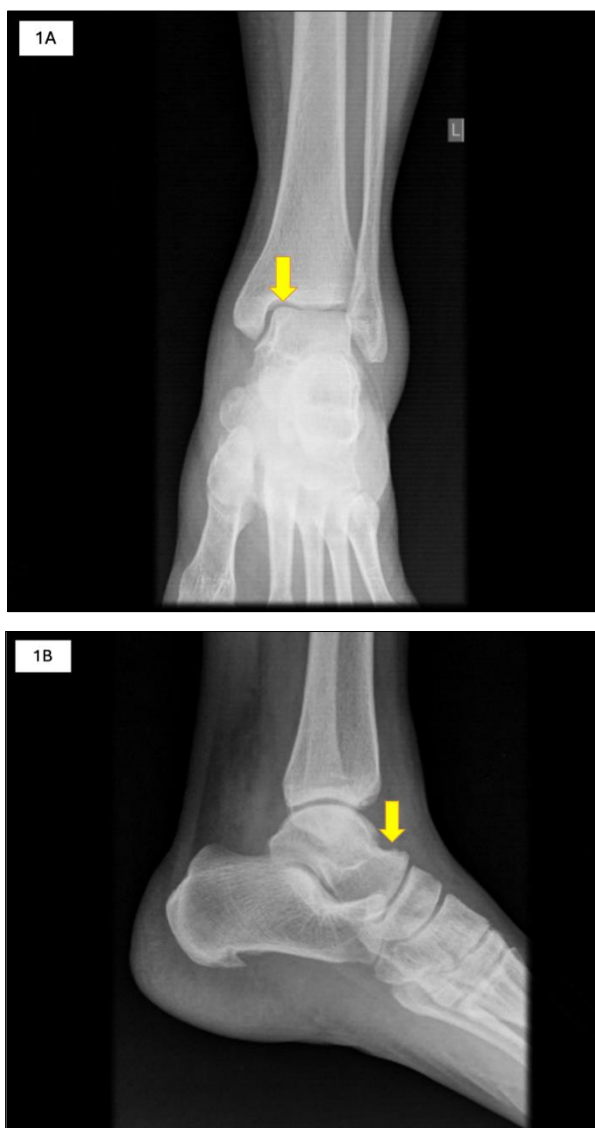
A 46-year-old female presented with complaints of pain and tenderness over the ventral aspect of the ankle joint. Radiograph of ankle joint AP View (A) showed osteochondral fragment at the medial aspect of the talar dome with a corticated outline and minimal separation. Lateral view (B) showed cortical irregularity in the anterior aspect of talus
